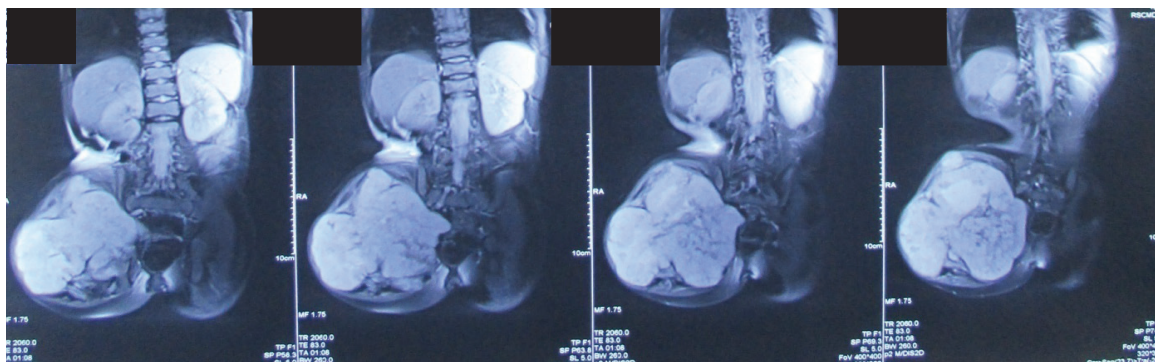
Coronal MRI showing the malignant chondroid lesion of the right ischium along with soft tissue tumour that involved gluteus maximus muscle, medius and minimus along with right piriformis. There was also an extension to intrapelvic organ and sciatic nerve.
